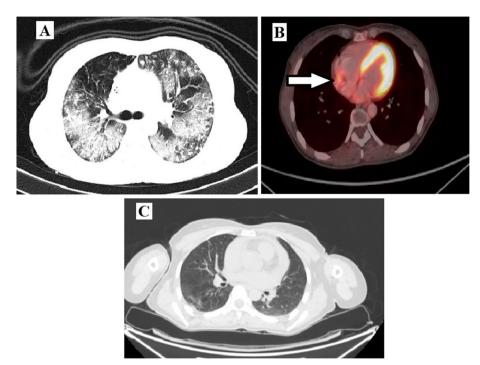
Initial CT and PET images (A and B) showing confluent areas of ground glass opacity involving the bilateral lungs and FDG avid right atrial mass. C Post-treatment scan showing resolution of initial CT changes
